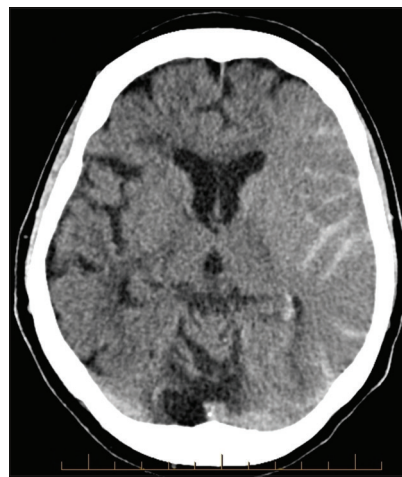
Conventional unenhanced CT showing diffuse subarachnoid hyperdensity of the left cerebral hemisphere.
